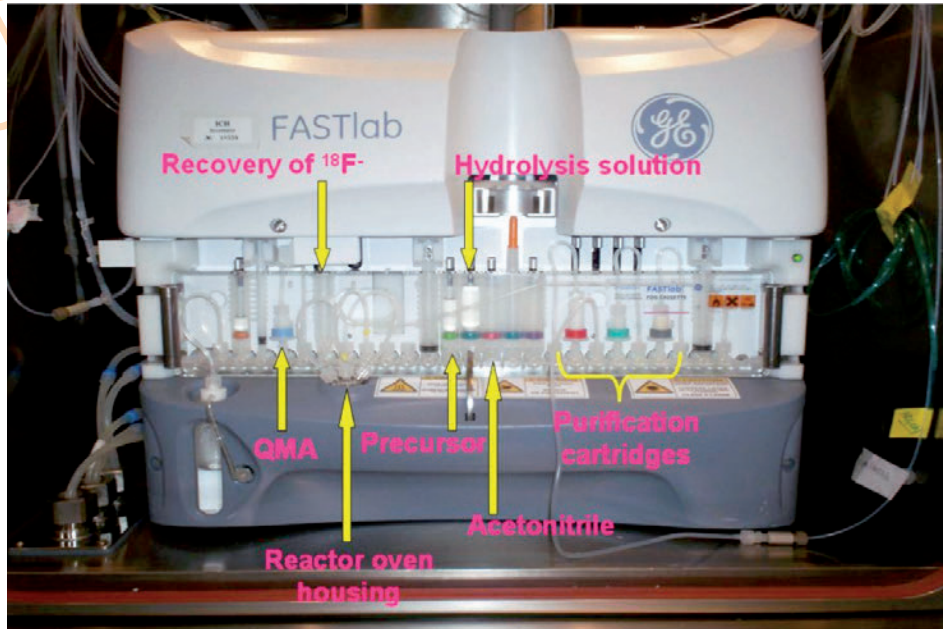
An example of an [ $^{18}\text{F}$ ]FDG module equipped with cassette: Fastlab GE
